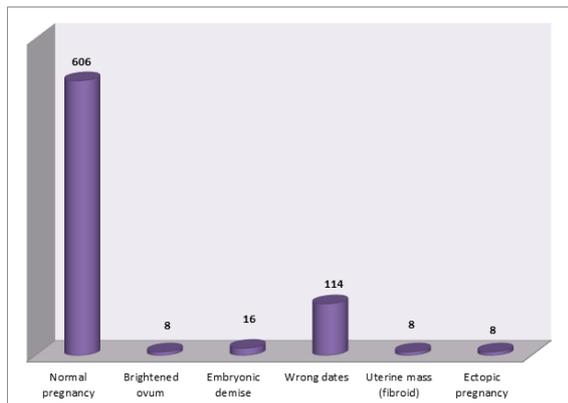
Findings of ultra sonography
